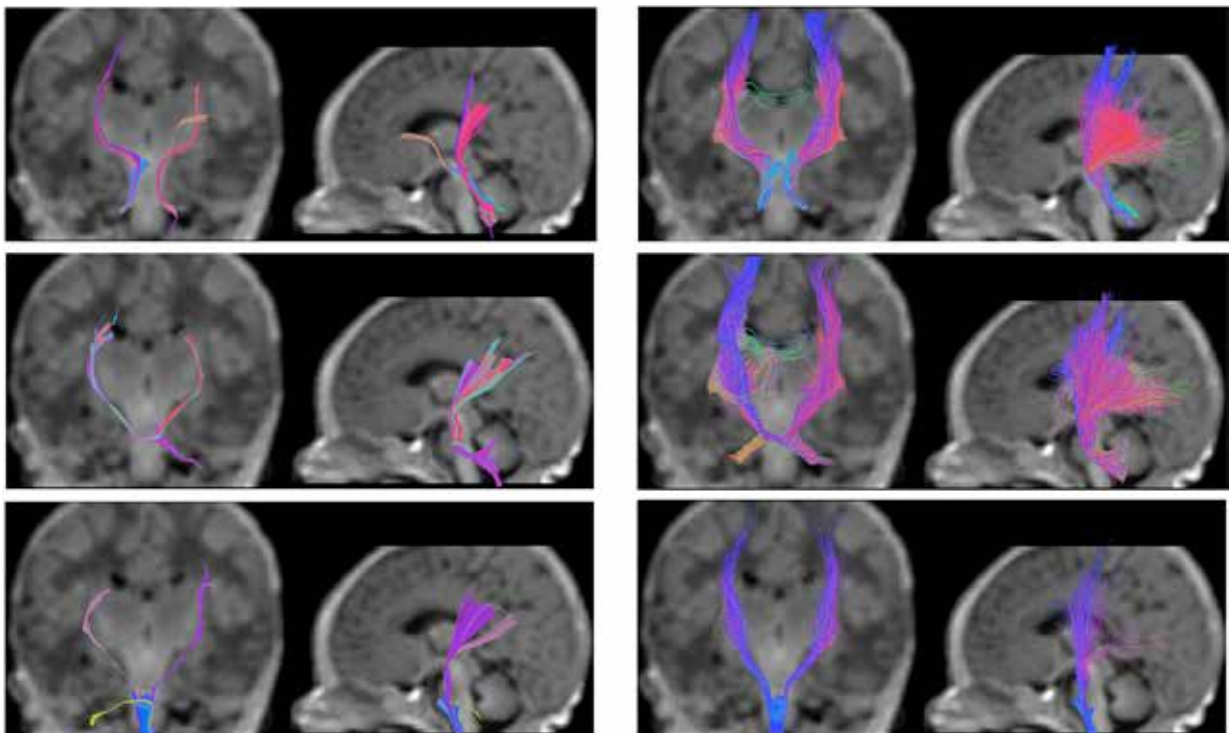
Comparison between deterministic (FACT) and probabilistic CSD tractography in a 3-day old neonate. The first column shows the reconstructed bundles for cerebellar-thalamic tracts (top row), corticopontocerebellar tracts (middle row) and corticospinal tract (bottom row) obtained with a traditional DTI deterministic tracking method (FACT), while the second column depicts the same reconstructed bundles obtained with probabilistic CSD tractography. Bundles are overlaid on coronal and sagittal T1-weighted images. Figures are representative of the global shape of the reconstructed bundles, irrespective of the cropping of the anatomic section.
